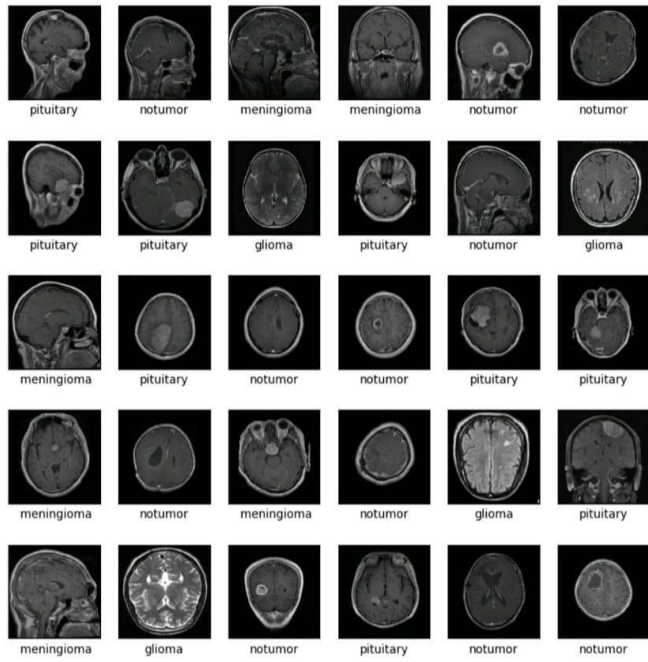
MRI scans, with a distribution of tumor types, including no tumor, pituitary, meningioma and glioma tumors.
